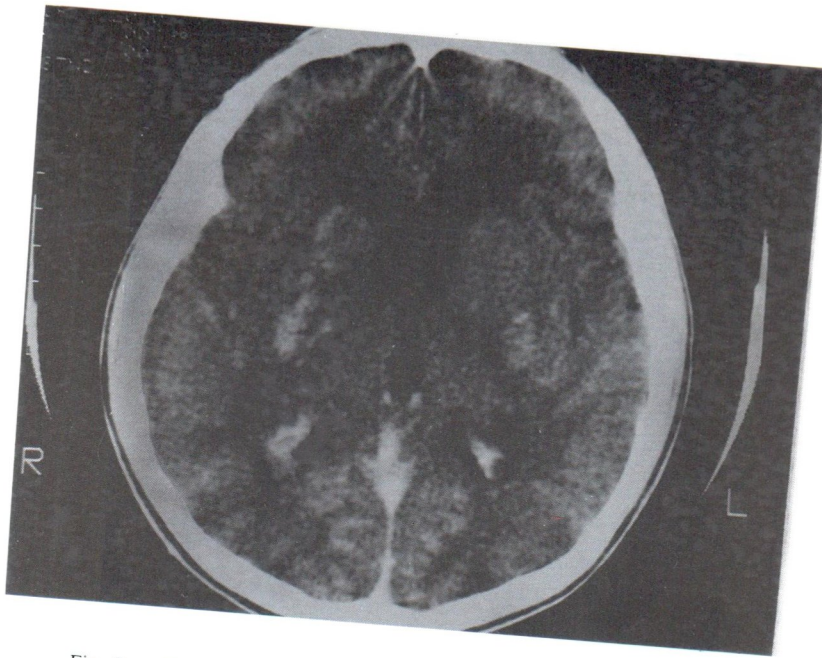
Enhanced CT scan showed patchy enhancement of both sides of basal ganglia and enlarged enhanced choroid plexus of both posterior horns, in cryptococcosis
